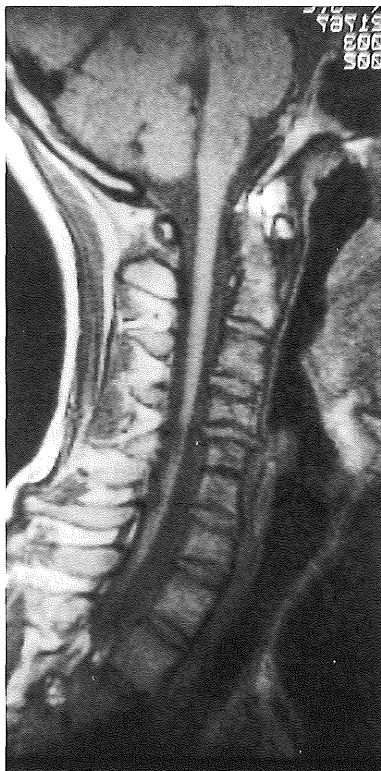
Case 1 – on MRI recently taken showed abnormal spinal cord, vertebrae and intervertebral disks. (18 years)
